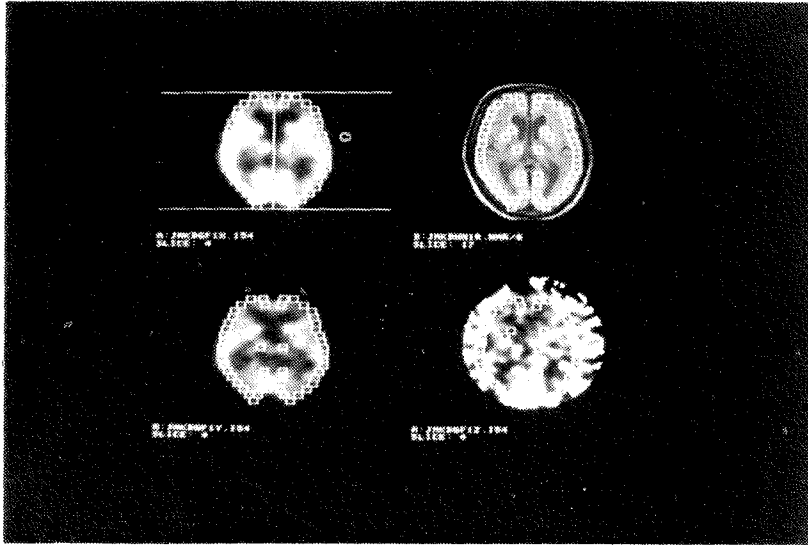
Counter clockwise from top left: PET image 1 from a behaviorally activated normal volunteer; PET image 2 from the same subject in the resting state. PET image 3 is a subtraction of PET image 2 from PET image 1; MR image at the same axial level as the PET images. All the PET images have been co-aligned to the MR image. Square 8×8 mm regions of interest in cortical and subcortical grey matter appear on the PET images at corresponding locations to those in the MR image.
